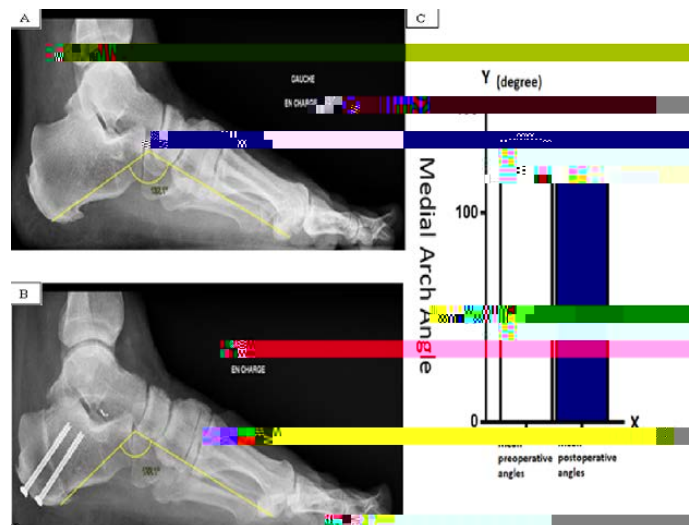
A) Axial Preoperative Medial Arche Angle Measurement on a Lateral Ankle Plain Radiograph. B) Postoperative Medial Arche Angle Measurement on a Lateral Ankle Plain Radiograph. C) Results of the Mean Distribution of the Medial Arche Preoperatively and Postoperatively.
